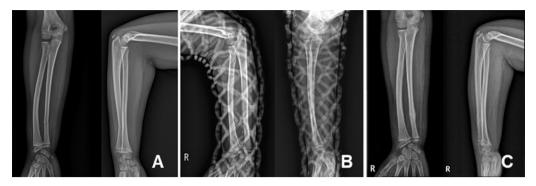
Initial X-ray for distal ulnar shaft fracture (a). Closed reduction with OPENCAST® (b). Last follow-up after eight weeks (c).
